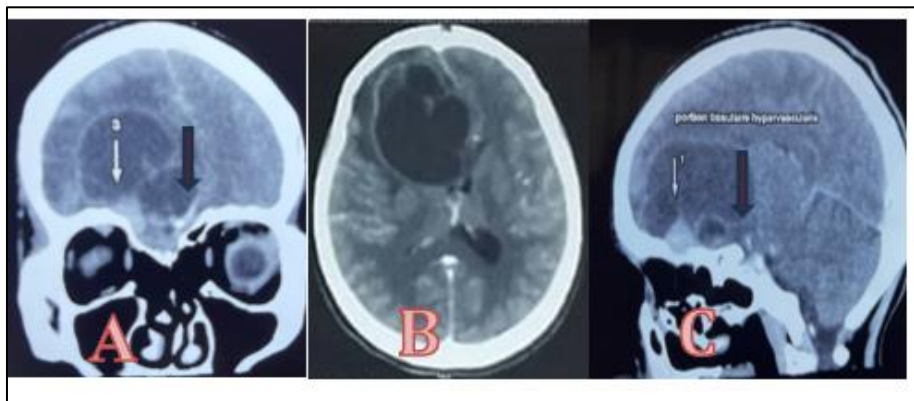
Cerebral CT scan in coronal (A), axial (B) and sagittal (C) sections shows a right basifrontal mass with a double component, fleshy (red arrow) and predominantly cystic
